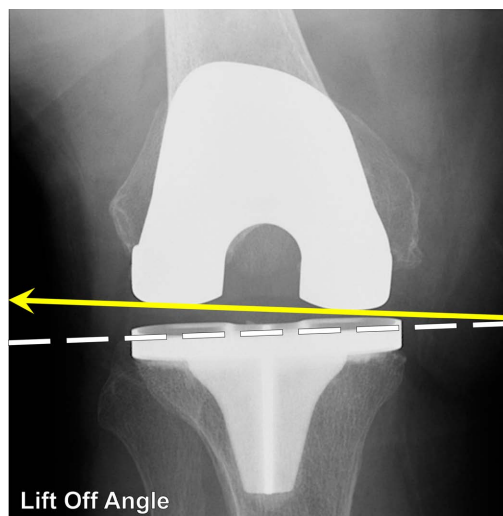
Evaluation of Flexion Stability. Lift-off angle (the angle between the tibial implant surface and distal femoral articular surface; the lateral joint opening was positive) was measured using the Axial Radiography (*Kanekasu's view*) [9].
